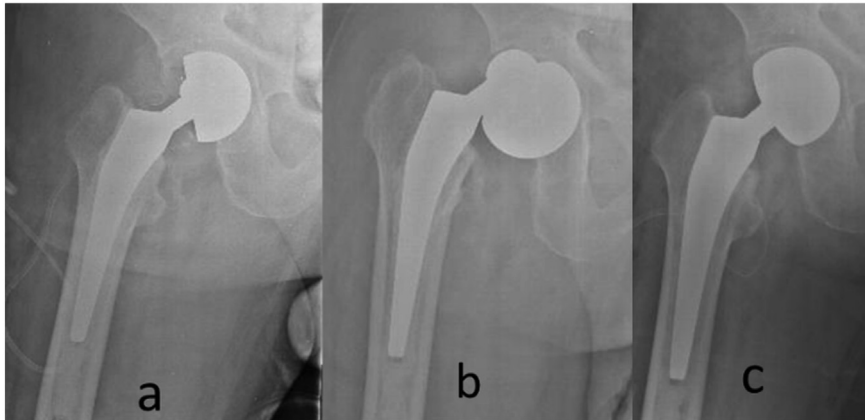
(a) Case 1: Plain roentgen showing initial excessive varus position of the bipolar cup. (b) Case 1: Plain roentgen revealing dissociation between bipolar components. (c) Case 1: post-operative image after revision of the bipolar components.
